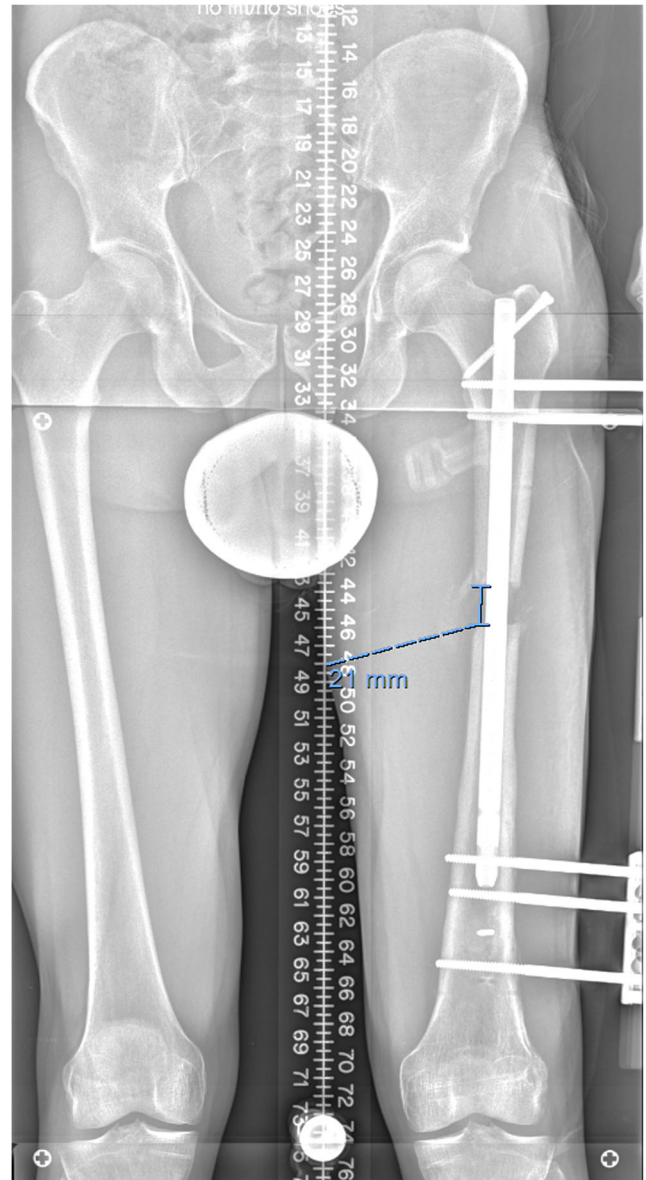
The same patient is seen after 21 mm of distraction. The bony gap measured on the radiograph and then compared with the number of millimeters the patient recorded turning the frame distractor.
